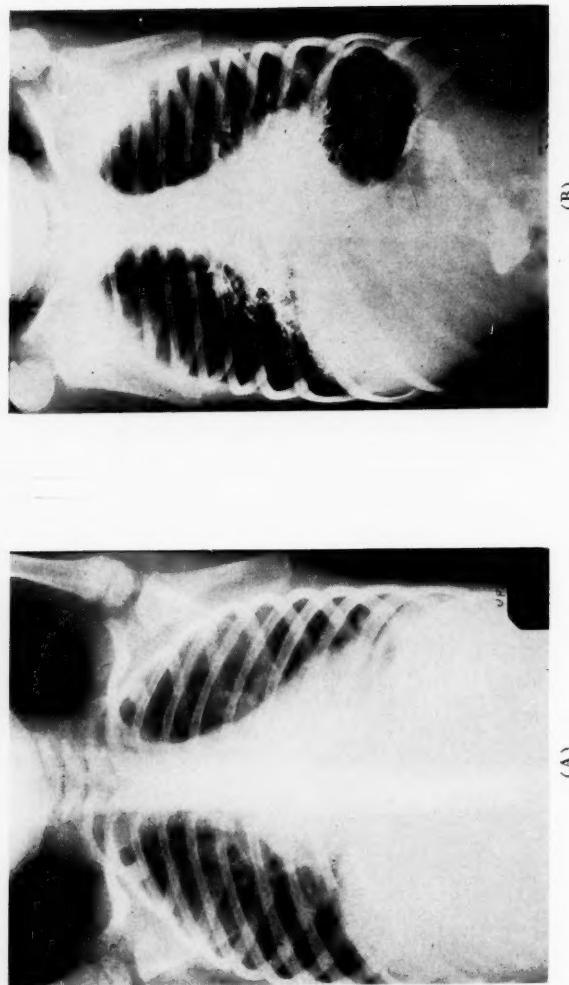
Radiographs of same patient shown in Fig. 3 after repeated aspiration of obstructing bronchial pus and dilatation of inflammatory bronchial stenosis. There has been a reeration of the atelectatic lower lobes (A), and the bronchography shows the size and distribution of the bronchi to be normal (B).
